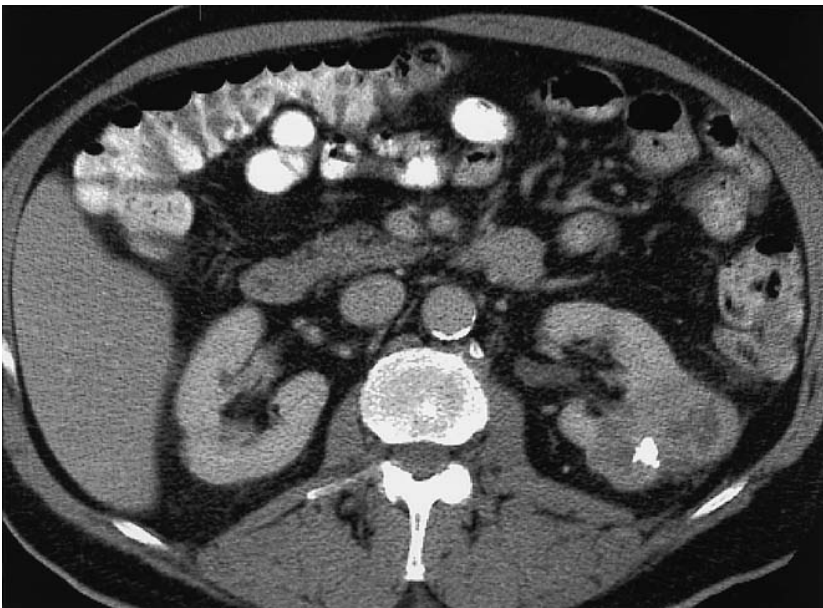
Standard enhanced axial CT image at 280 mA for staging of the same 5 cm left renal mass demonstrates heterogenous enhancement typical of renal cell carcinoma. Nephrectomy demonstrated renal cell carcinoma, stage 1, grade 2.
